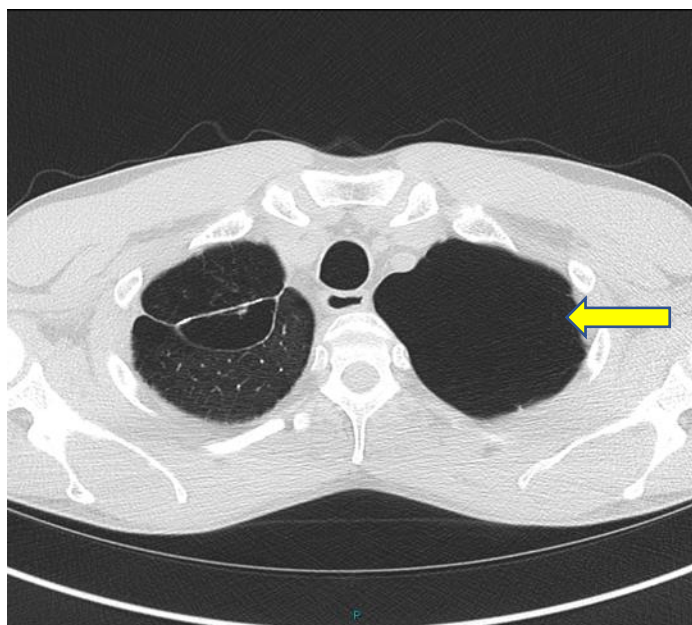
CT scan of a patient at Liverpool Heart and Chest Hospital showing bullae in the left upper lobe (yellow arrow).
